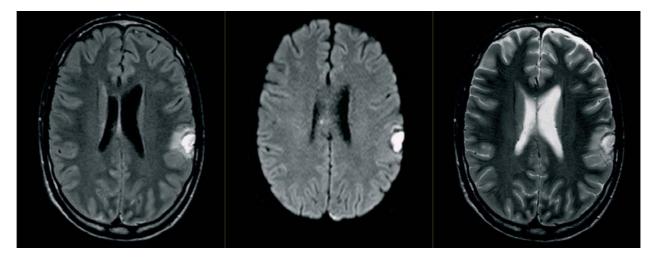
From left to right: axial T2, DWI and FLAIR sequences of brain MRI performed nine days after the previous one, which showed reduction of both contusive lesions and subarachnoid hemorrhage and diffuse axonal damage.
